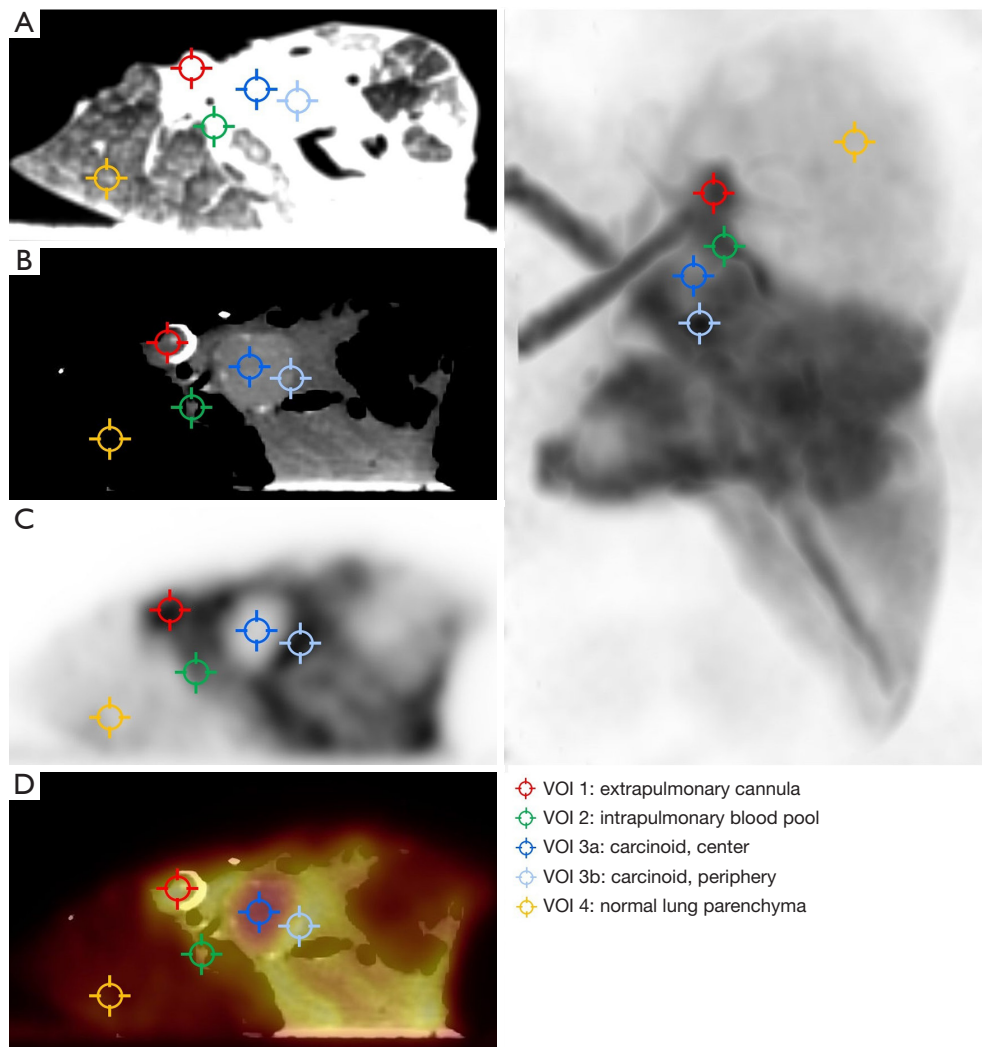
Defined volumes of interest in a transversal plane. (A) Lung window in computed tomography. (B) Mediastinal window. (C) PET image. (D) Fused PET/CT; right panel: multiplanar projection of PET images in coronal view. VOI, volume of interest; PET, positron emission tomography.
